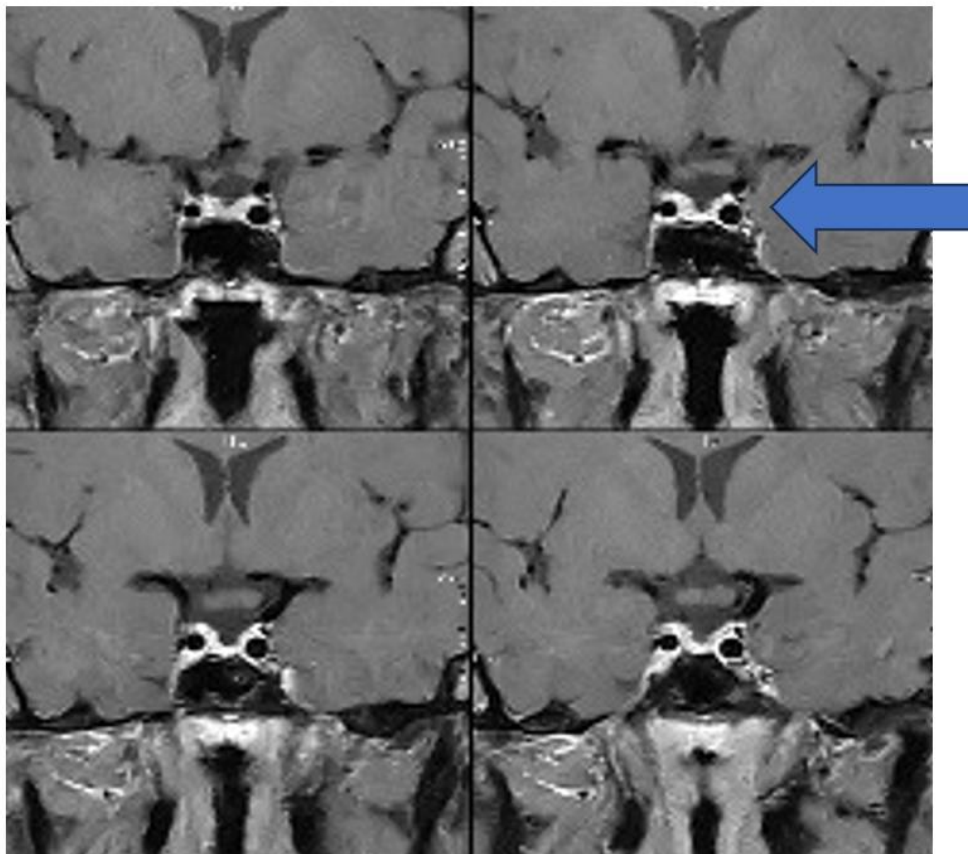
Contrast enhanced MRI of the sella demonstrating a partially empty sella with a markedly thinned pituitary gland measuring approximately 2 mm in height along with absent pituitary stalk.
